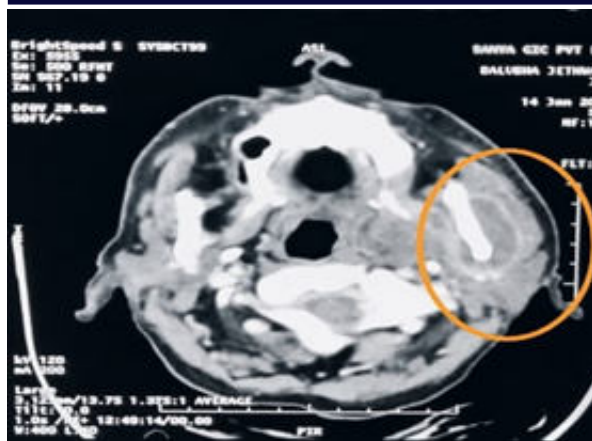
CT-Scan neck showing collection in superficial lobe of left parotid gland.
